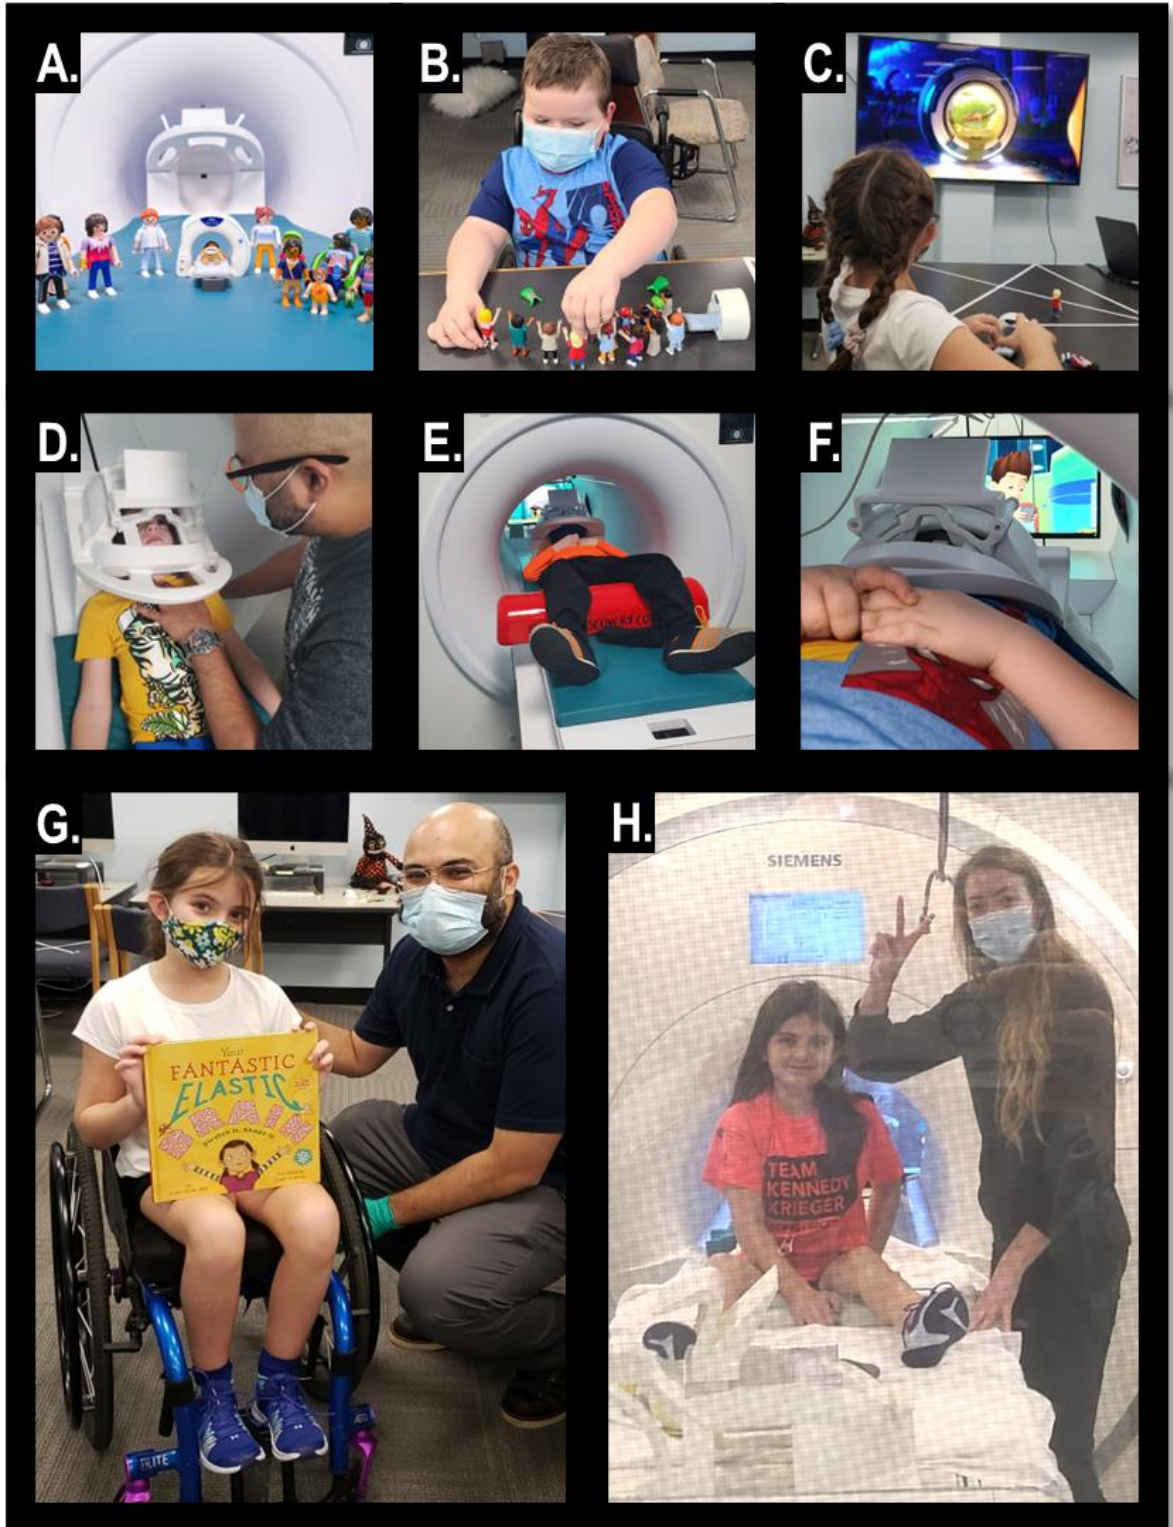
Using games and interactive tools to prepare children for MRI scans.
